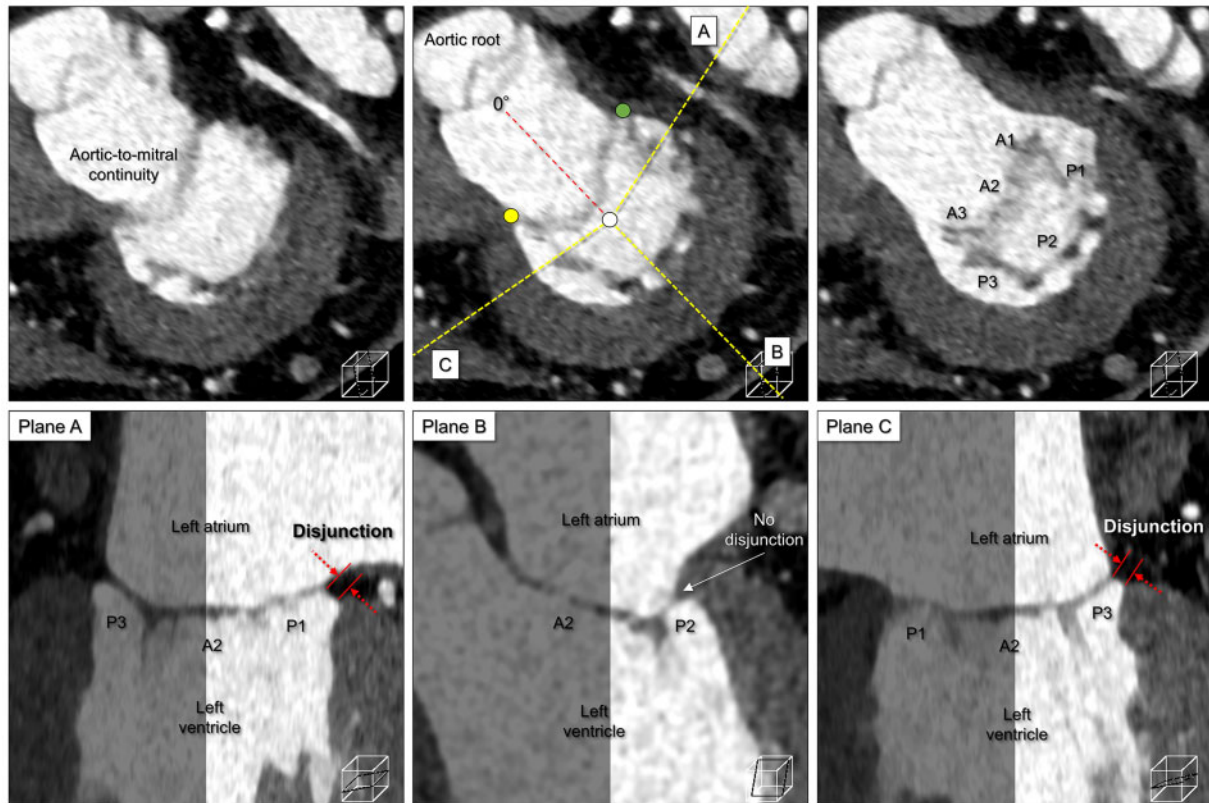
Qualitative measurements of distribution and height of disjunction using computed tomography. Serial multiplanar reconstruction images focusing on short-axis images of the left atrioventricular junction showing the mitral orifice plane (upper middle panel) with its adjacent basal (upper left panel) and apical (upper right panel) planes during systole. The mitral orifice plane was created to involve the supero-lateral commissure (green circle), infero-medial commissure (yellow circle), and centre of the attachment of the P2 scallop. The bilateral commissure point can be determined using these serial images. Yellow dashed line A–C corresponds to multiplanar reconstruction images orthogonal to the mitral orifice plane (lower panels). The white circle indicates the central longitudinal axis of rotation.
